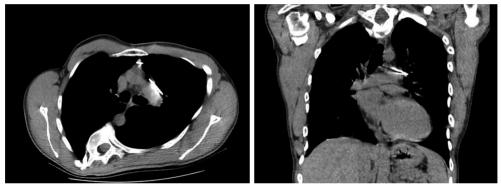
Thoracic computed tomography images showing close proximity of K-wires to ascending aorta and left pulmonary artery.
